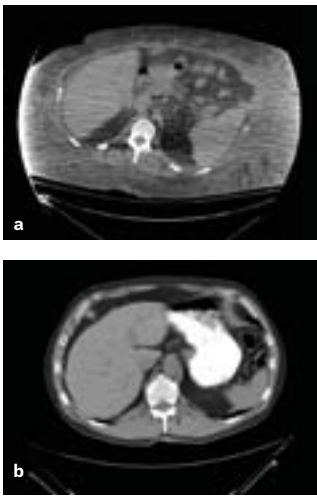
Axial CT Image of an Obese Patient
